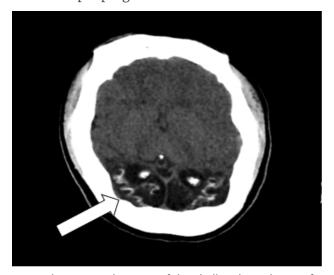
Computed tomography scan of the skull with evidence of cortical laminar necrosis in the occipital region.
